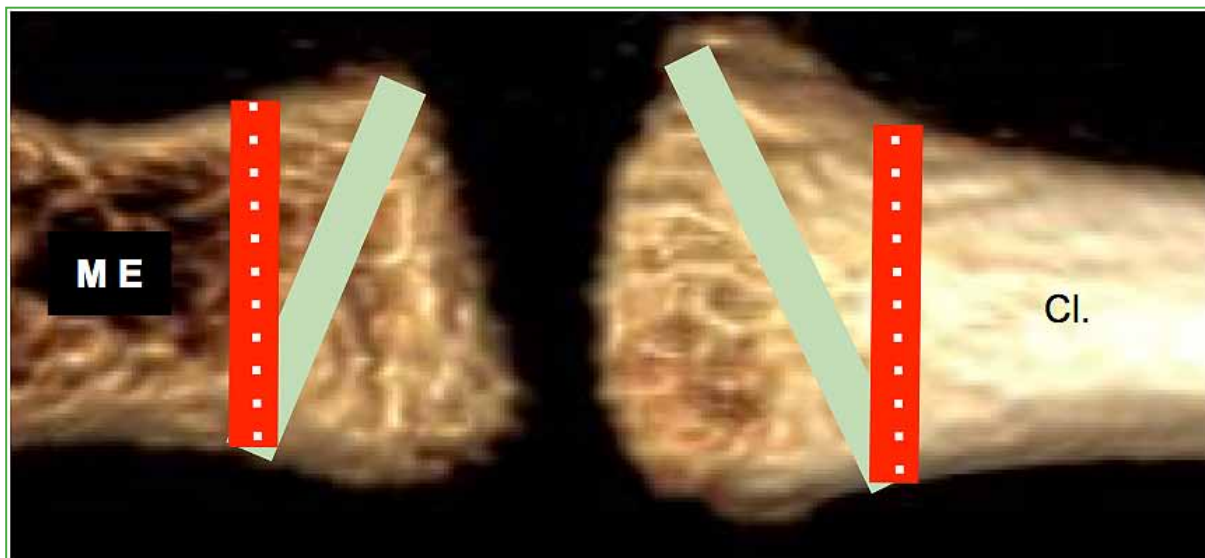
CT of the sternoclavicular joint with 3-D reconstruction, craniocaudal view. The red line with white dots shows the direction of the classic figure-of-eight reconstruction with perpendicular anteroposterior tunnels. The solid green line shows our modification with oblique tunnels, which facilitates and shortens the procedure, decreases the graft path and offers greater length for anterior closure, and reduces risk and tissue damage without significant injury to the articular surface.
